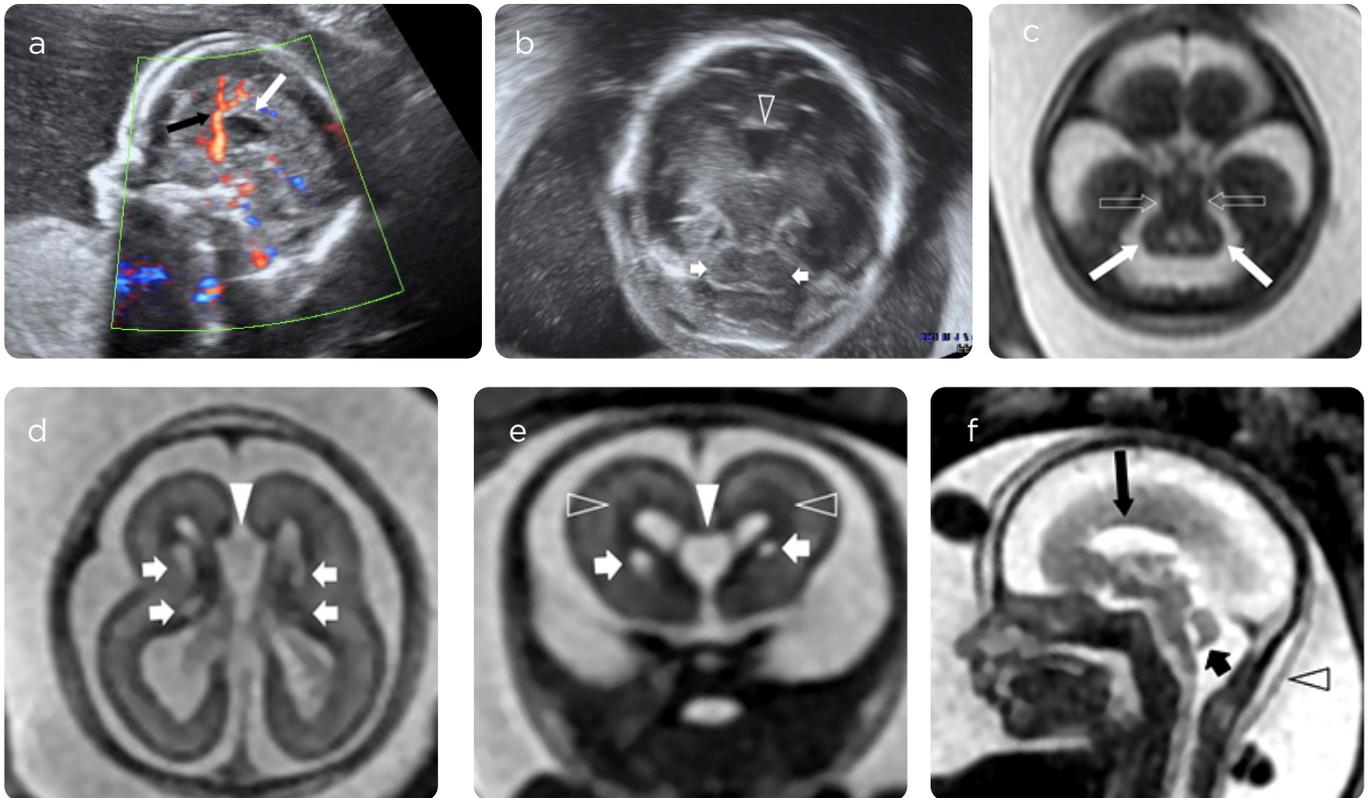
Bilateral cavitations in ganglionic eminences. Fetal ultrasound. Gestational age 20 weeks and 1 day. a) Neurosonography with mid-sagittal plane. The trunk of the corpus callosum is identified (solid long white arrow) with absence of the knee and splenium. The pericallosal arteries have a cranial direction without describing the typical semicircle around the corpus callosum (solid long black arrow). b) Axial plane neurosonography with hypoplasia of the cerebellar hemispheres (solid white arrows). Cerebellar transverse diameter 15.8 mm. Area of the cerebellar hemisphere 40 cm² and of the left cerebellar hemisphere 41 cm². Prominent cavum septi pellucidum (empty white arrowhead). Fetal MRI. Gestational age 20 weeks and 5 days. c) Axial FIESTA sequence. d) Axial e) Coronal f) Sagittal SS FSE sequences with T2 information. Marked hypoplasia of both cerebellar hemispheres (solid long white arrows) and to a lesser extent of the vermis (solid short black arrow). Horizontalization and thickening of the superior cerebellar peduncles with molar-like malformation image (empty long white arrows). Prominent cavum septi pellucidum (solid white arrowhead). Microcephaly with prominent ganglionic eminences in the germinal matrix showing bilateral and symmetrical cavitations with C-shaped morphology without indentation (short solid white arrows). No intermediate neuromas layer is identified between the very prominent ventricular zone neuron layer (empty white arrowheads) and the immature outer cortex, future banded heterotopias with microlisencephaly. Nuchal fold thickening of 4.5 mm (empty black arrowhead). Dysgenesis of the corpus callosum visualizing the trunk of the corpus callosum (long solid black arrow) with absence of its knee and splenium.
